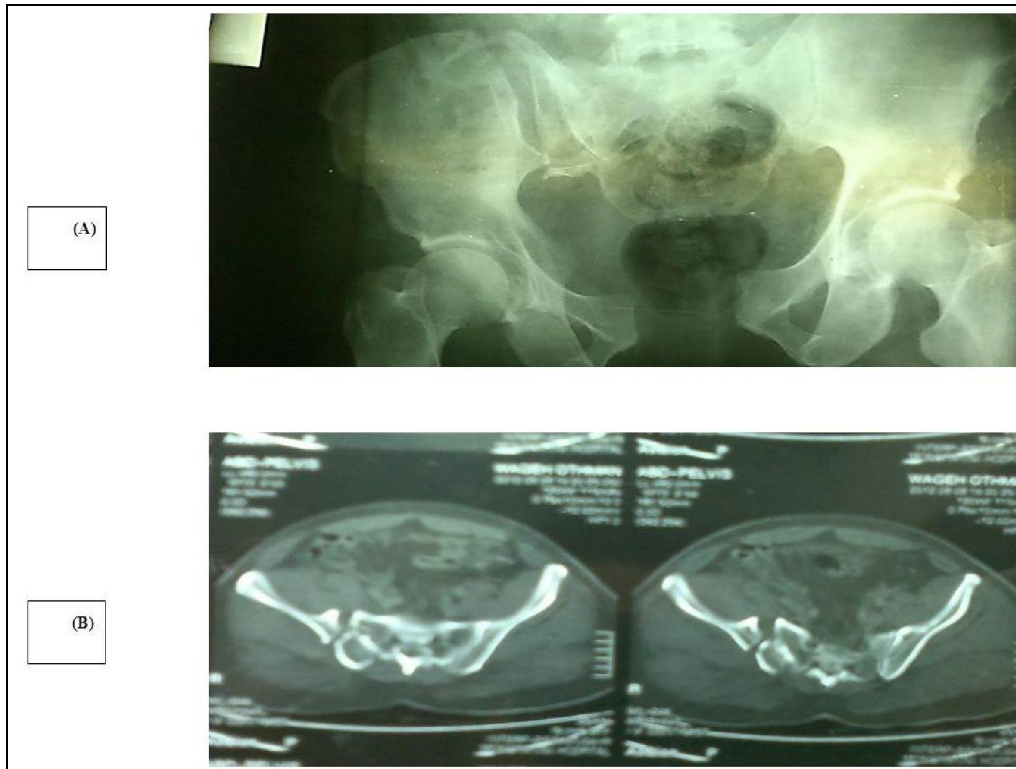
Preoperative plain X ray antero-posterior view and axial CT.
